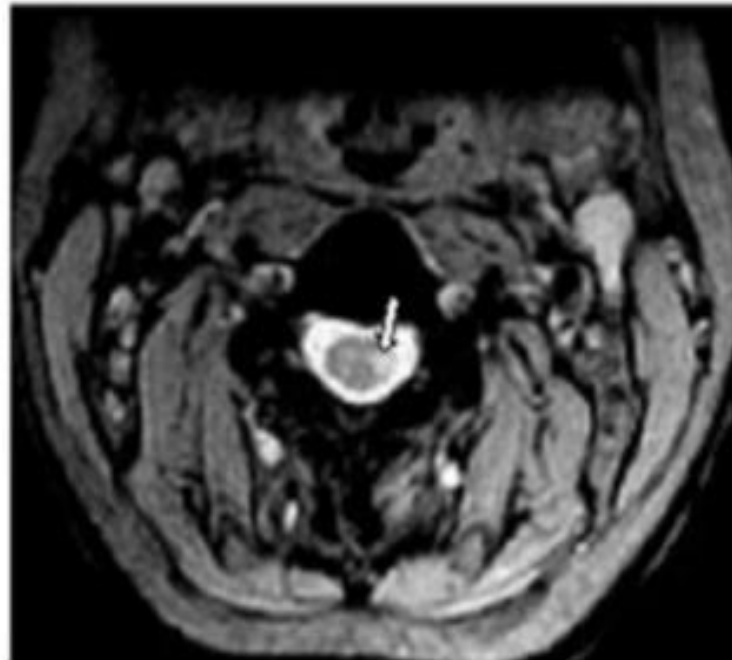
(Right) Sagittal T2 shows discrete lesions without cord swelling (between arrows), (left) On an axial T2-weighted image a triangular shape and are located laterally (arrow head) is involved and shows a hyperintense signal suggesting MS.
